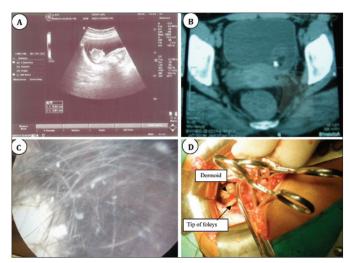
(A-D): (A) Ultrasound showing right adnexal mass extending in to the bladder. (B) CT Scan showing calcified mass in the bladder. (C) Cystoscopic picture of dermoid with hair protruding from it. (D) Intraoperative findings of open bladder with dermoid cyst.
